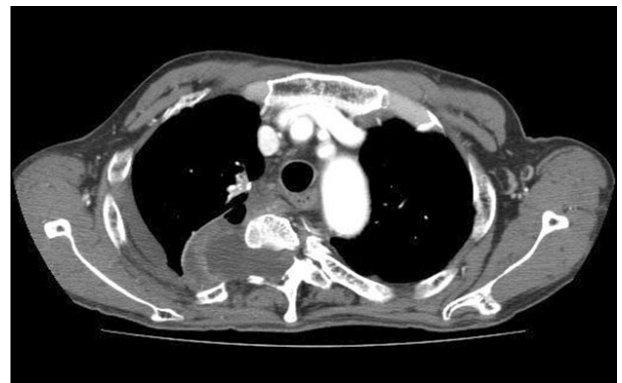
Preoperative chest computed tomogram (A) shows an approximately 7.5-cm cystic mass arising from the right side of the T4 spinal canal. A T2-weighted magnetic resonance image (B) shows CSF signal intensity meningeal protruded cystic lesion(s) through the right neural foramen at T2 (1.5×0.9 cm).
